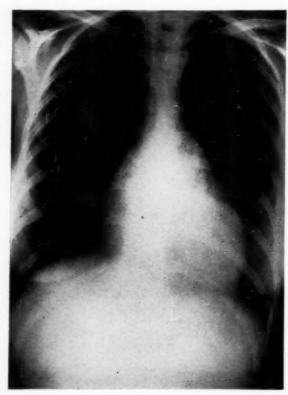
Roentgenogram of chest of 24-year-old white woman, anterolateral position, showing prominent convexity in lower half of right side of heart due to right atrial enlargement and fullness of right ventricular outflow tract.
